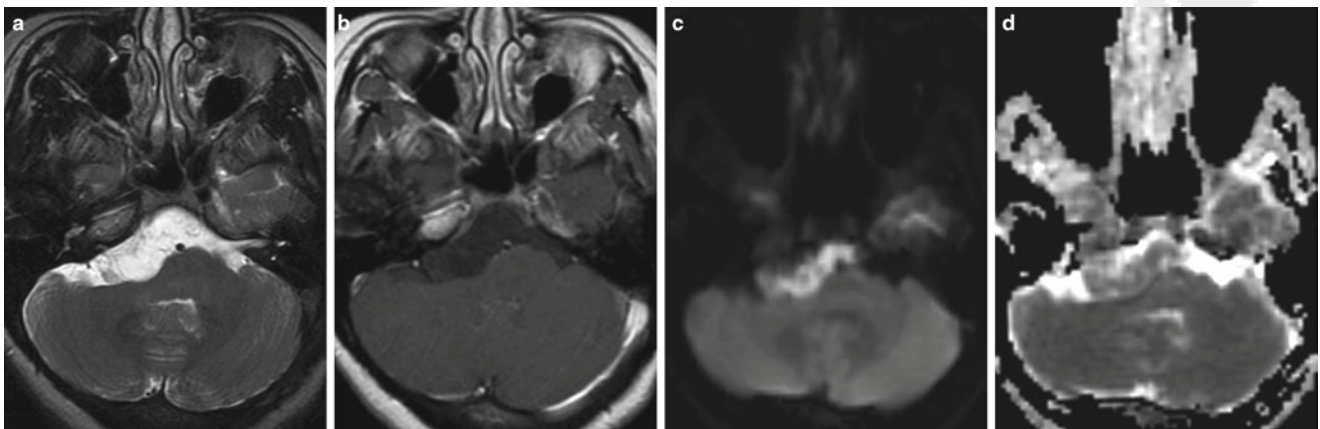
Epidermoid tumor. (a) Axial T2, (b) contrast-enhanced T1, (c) DWI, and (d) ADC images demonstrate an insinuating nonenhancing extraaxial lesion anterior to the lower pons and right middle cerebellar peduncle that has signal characteristics similar to CSF on T1- and T2-weighted sequences, but is markedly hyperintense to CSF on DWI
